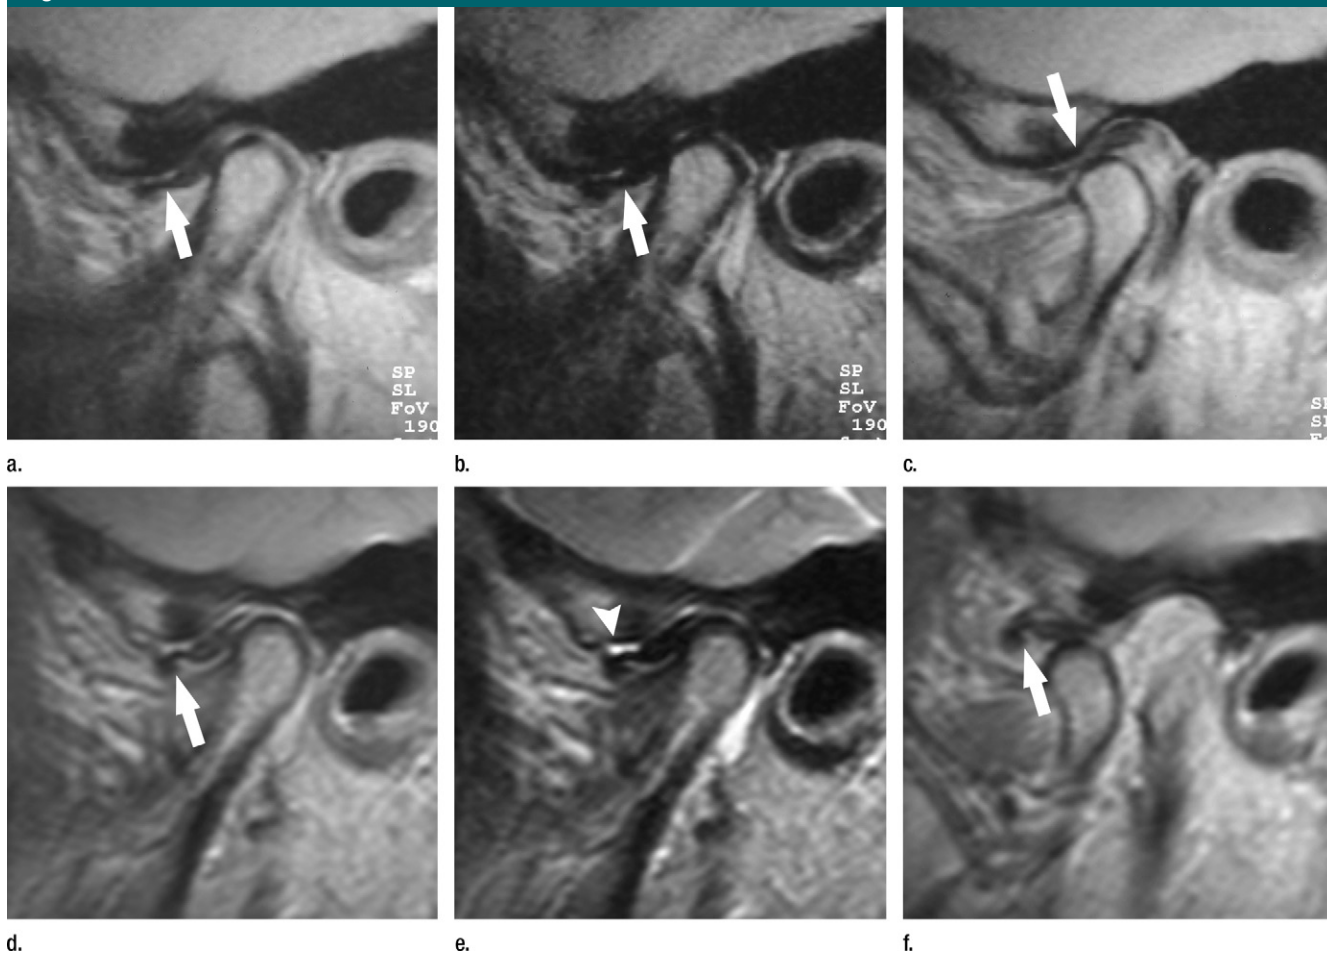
MR images show progression of a TMJ disorder in a 62-year-old woman (47 years old at study inception). (a, b) Sagittal proton density-weighted (2199/17) (a) and T2-weighted (2199/85) (b) images obtained at inception in closed mouth position show anteriorly displaced disk (arrows). (c) Proton density-weighted sagittal image (2199/17) obtained in open-mouth position shows reducing disk (arrow) at inception. (d–f) Corresponding images obtained at 15-year follow-up (4000/19, proton density-weighted images; 4000/112, T2-weighted images) show the progression to nonreducing disk (arrow, d and f) and effusion (arrowhead, e).
